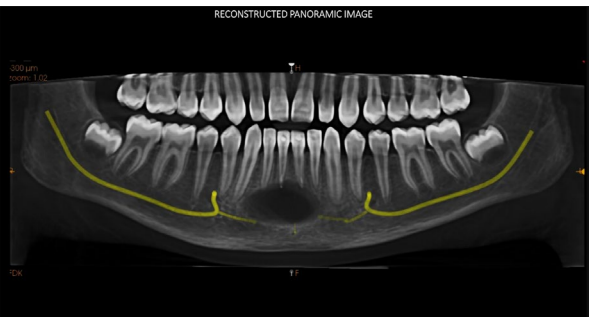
CBCT reconstructed panoramic image showing the lesion and the course and the proximity of bilateral mandibular incisive nerve
